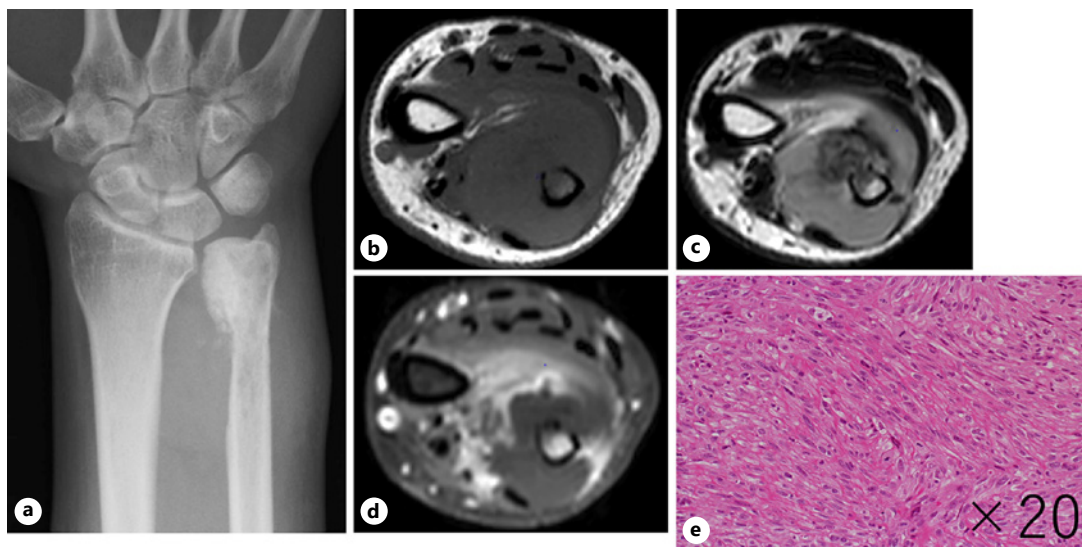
Image findings 8 months after the initial surgery. a Radiograph showed an ossified lesion with a multilobular surface in the distal ulna, with an associated soft tissue mass. b–d MRI showed a T1 low-signal (b), T2 high-signal (c), gadolinium contrast-enhanced (d) tumor approximately 8 cm in size with bony destruction and extraskelatal infiltration. e Incisional biopsy showed spindle cell proliferation in a fascicular pattern with marked nuclear atypia, mitosis, and osteoid formation, suggesting a high-grade osteosarcoma.
